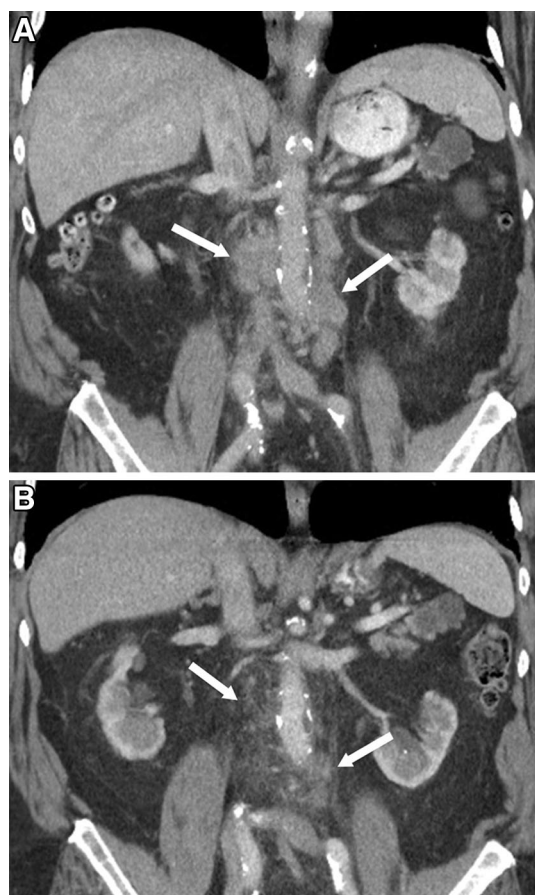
91-year-old man with urothelial carcinoma of bladder, with retroperitoneal nodal spread of disease, responding to adjuvant treatment with PD-1 inhibitor. A Coronal contrast-enhanced CT image demonstrates multiple enlarged retroperitoneal lymph node metastases (*white arrows A*). Follow-up coronal contrast-enhanced CT image at the same level after 12 weeks of treatment with PD-1 inhibitor demonstrates significant interval decrease in retroperitoneal lymph nodes representing response to treatment (*white arrows B*).
